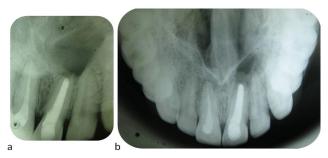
a) IOPA in relation to 11 & 21, b) Occlusal view radiograph of the maxilla after a follow up of 1yr
